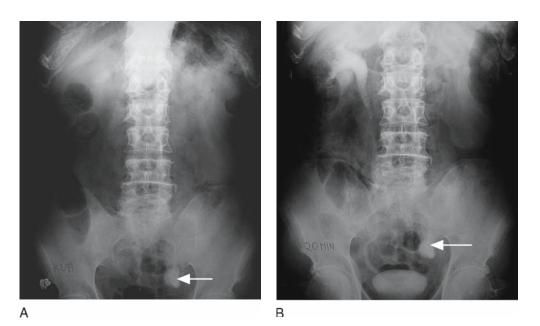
Plain x-ray and intravenous urogram (IVU) shows a large radiopaque shadow below the left sacroiliac joint and poorly functioning lower moiety (note that the upper calyx is seen faintly)
